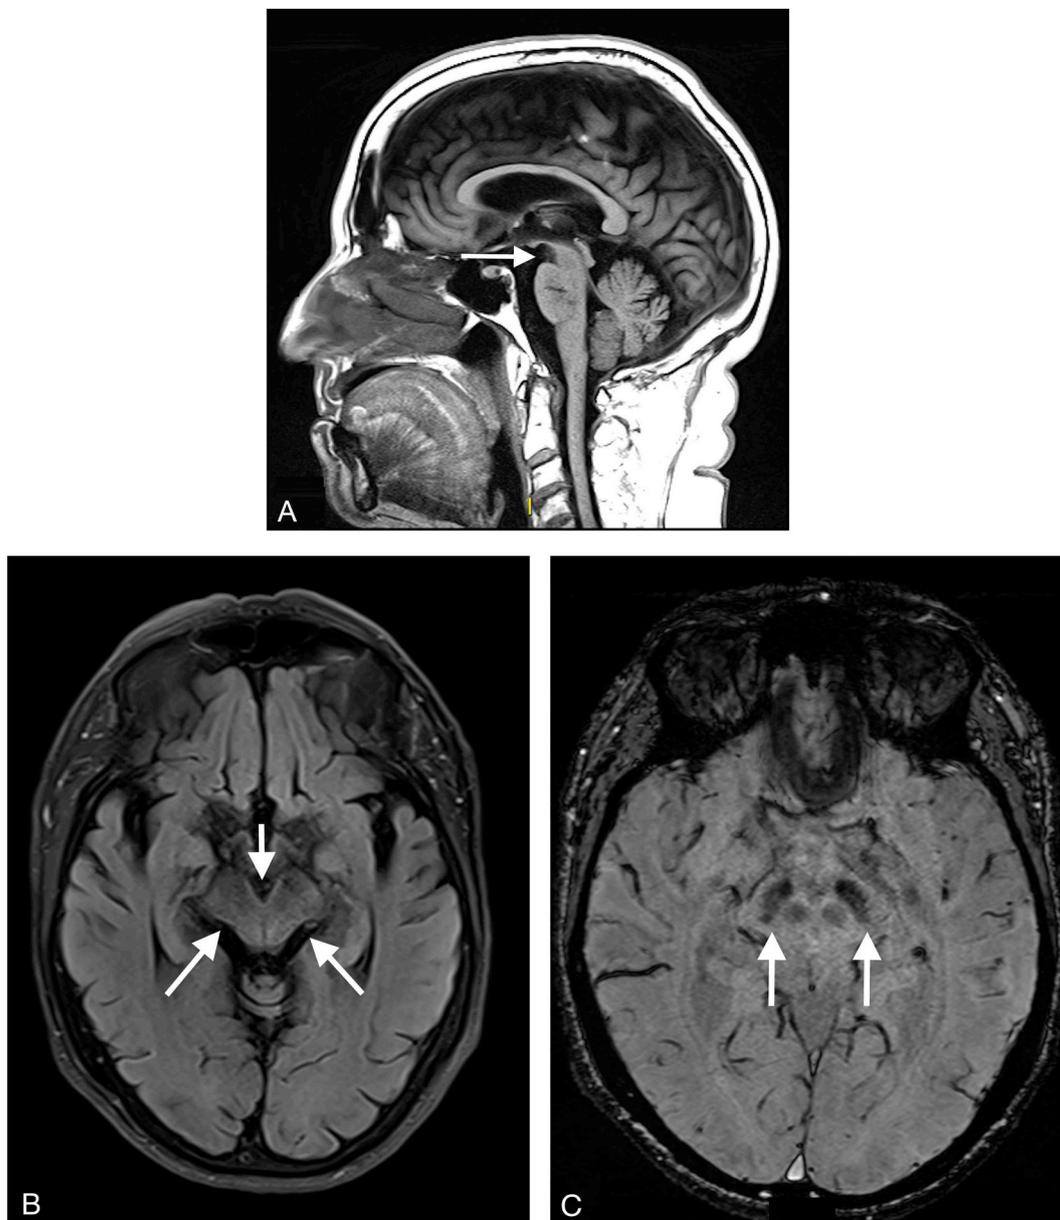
A–C (Patient's brain MRI): A: Sagittal T1-weighted sequence revealing mild mesencephalic atrophy resembling the hummingbird sign (white arrow); B: Axial Flair-weighted sequence showing mesencephalic atrophy with interpeduncular fossa enlargement and postero-lateral concavity (white arrows); C: Axial susceptibility-weighted imaging showing reduced nigrosome-1 in posterior aspect of substantia nigra probably related to nigro-striatal pathway degeneration. Her middle cerebellar peduncle (not shown here) was normal.
